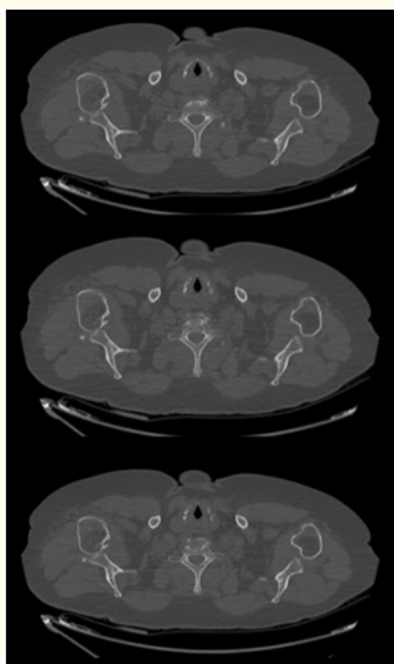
CT SCAN at the ED, Showing and gleno-humeral dislocation an gleonid rim fracture.
